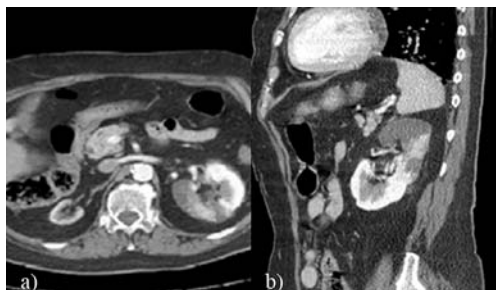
CE-CT scan of the abdomen a) transversal view – multiple hypodense areas in the left kidney and calcifications within the aorta; b) sagittal view showing the extensive avascular areas.
